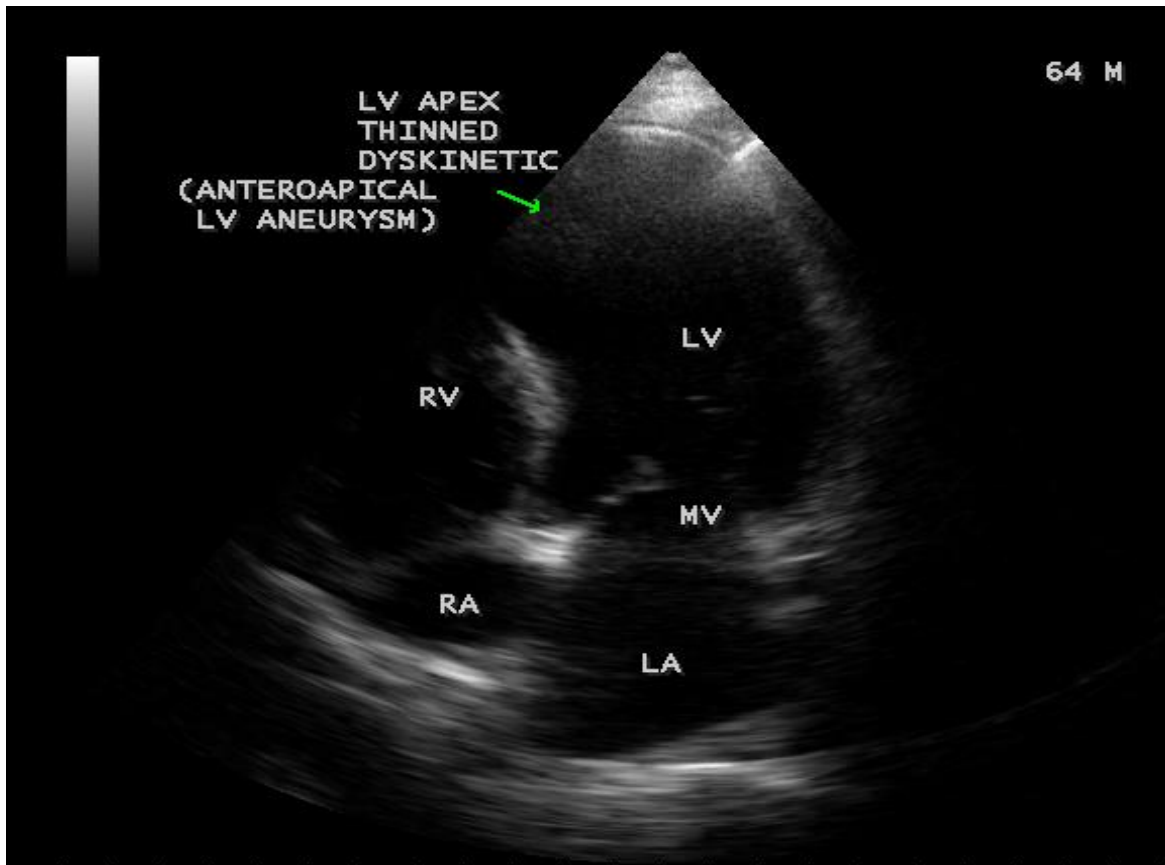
Apical Four chamber view showing the thinned, dyskinetic anteroapical septum with aneurysm [19].
